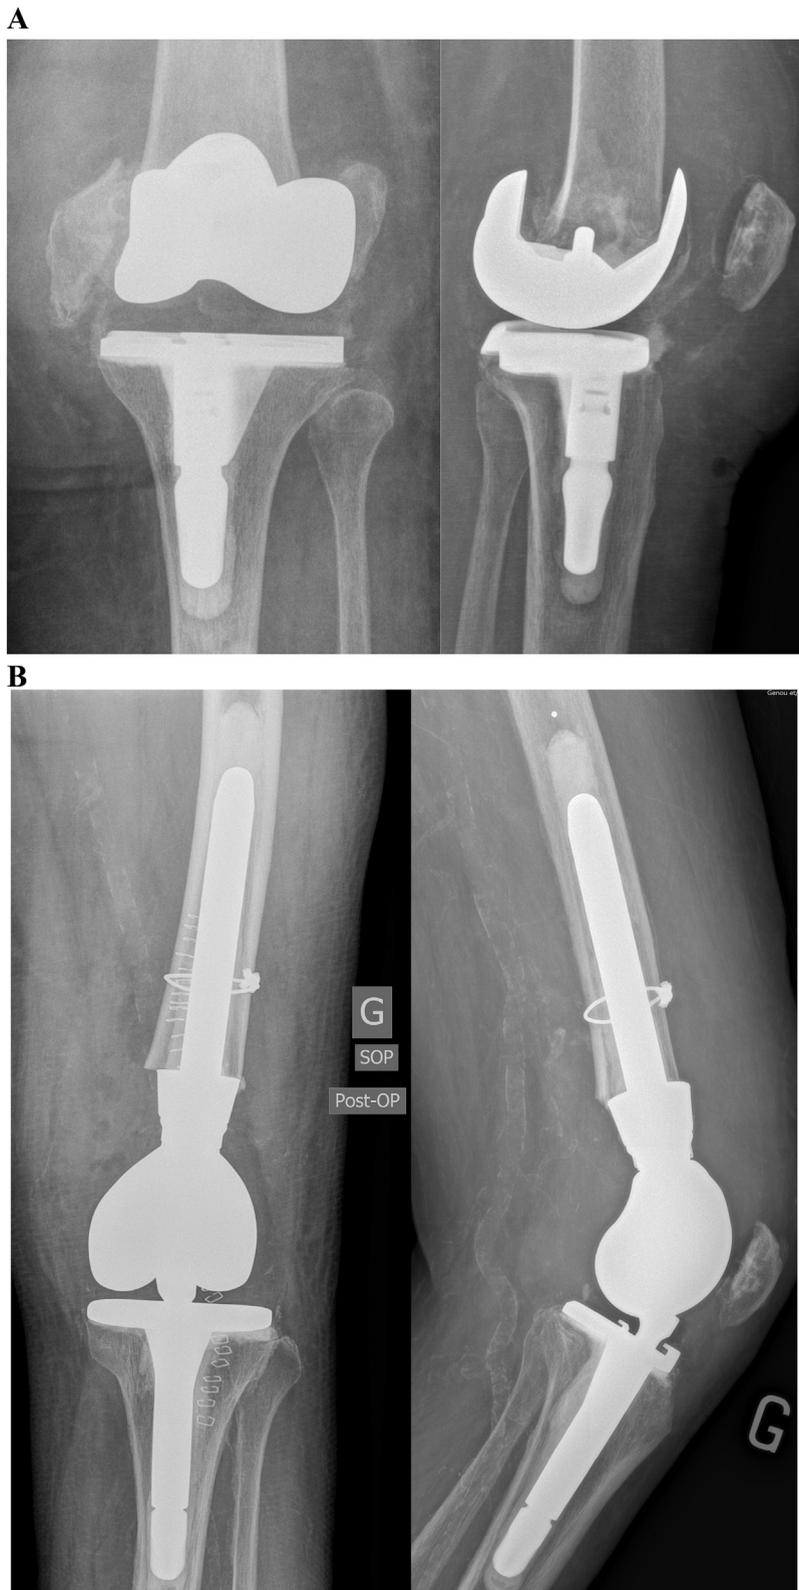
A & B. Pre-operative and post-operative X-rays for a 77 year-old female who sustained a distal supracondylar fracture from a fall three weeks following her initial TKA.
